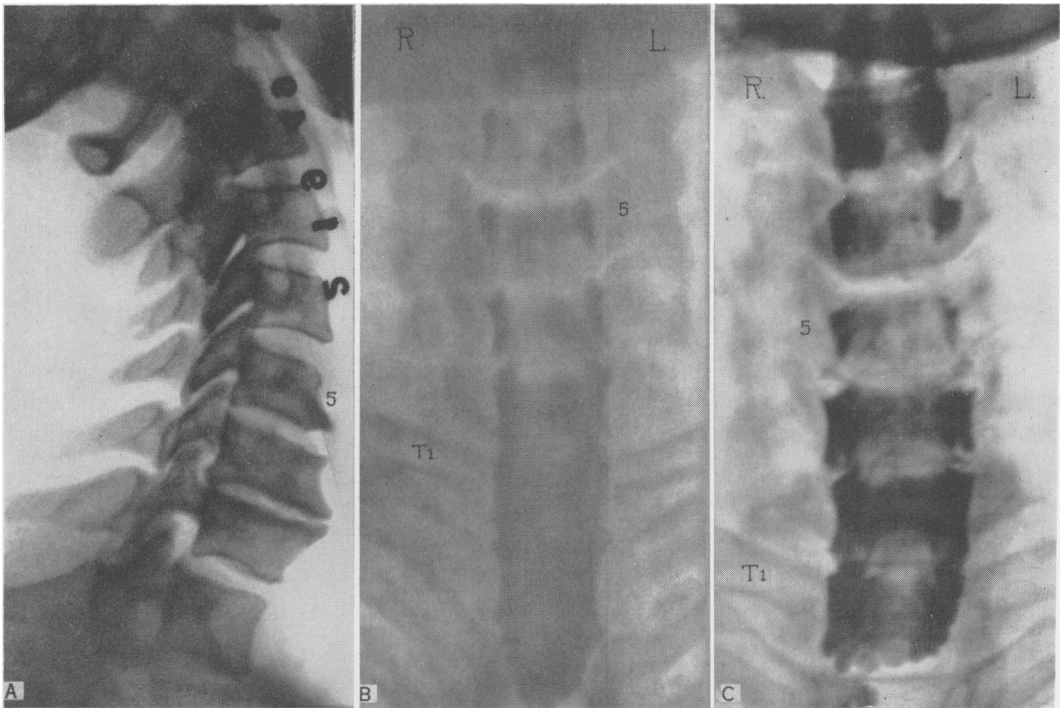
(Case 1). (B) Lateral roentgenogram taken 4 years before onset of major symptoms (1949), showing narrowing interspaces C₅ and C₆; slight subluxation C₇-T₁; anterior lipping. Note especially the posterior osteophytic overgrowth of Vertebrae C₅ through C₇. (A) Myelogram (1949) showing radiolucency at C₃ through C₆ interspaces. (C) Repeat myelogram 4 years later (1953); essentially same findings.
